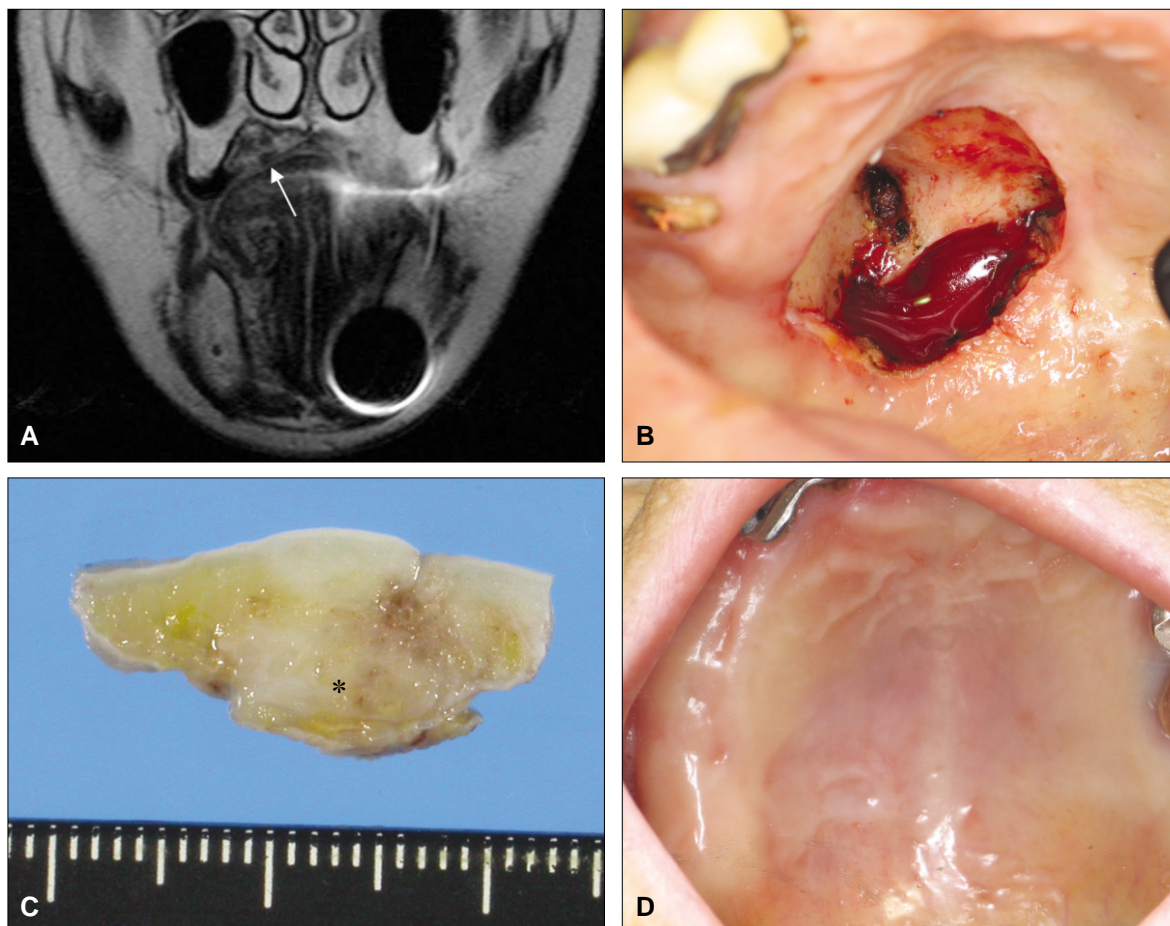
Perioperative radiologic and clinical features. A. In preoperative MRI view, well demarcated firm mass was observed under the palatal mucosa (white arrow). B. After removal of tumor, intact hard palatal bone was detected. C. Main mass (*), approximately 1.5x1 cm size, was resected with peripheral normal tissues. D. After 6 months of operation, completely healed palatal mucosa was observed. (MRI: magnetic resonance imaging)
